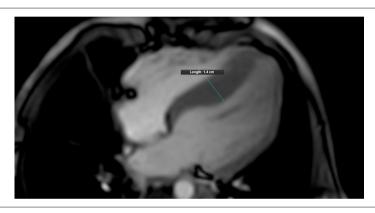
Four-chamber cine-mode magnetic resonance imaging. Male patient, 3 years old, with family history of hypertrophic cardiomyopathy. Asymmetric septal hypertrophy is observed with maximum thickness of 1.4 cm.
